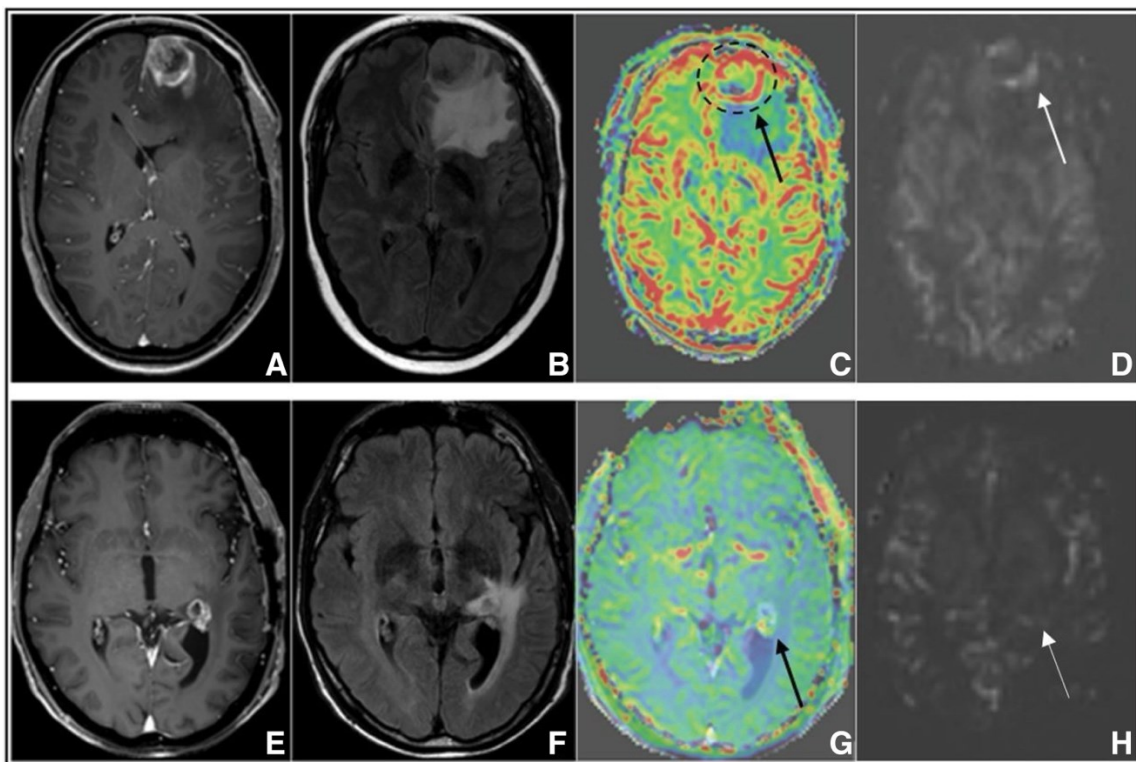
Representative post-contrast T1-weighted images (A, E), T2 FLAIR sequences (B, F), dynamic susceptibility contrast-derived relative CBV (DSC-rCBV) maps (C, G), and arterial spin labeling CBF (ASL-CBF) maps (D, H) are shown for two patients: one with confirmed TP (top row, A–D) and one with confirmed PsP (bottom row, E–H). *Adapted from (van Dorth et al., 2025), licensed under CC-BY-4.0.*
